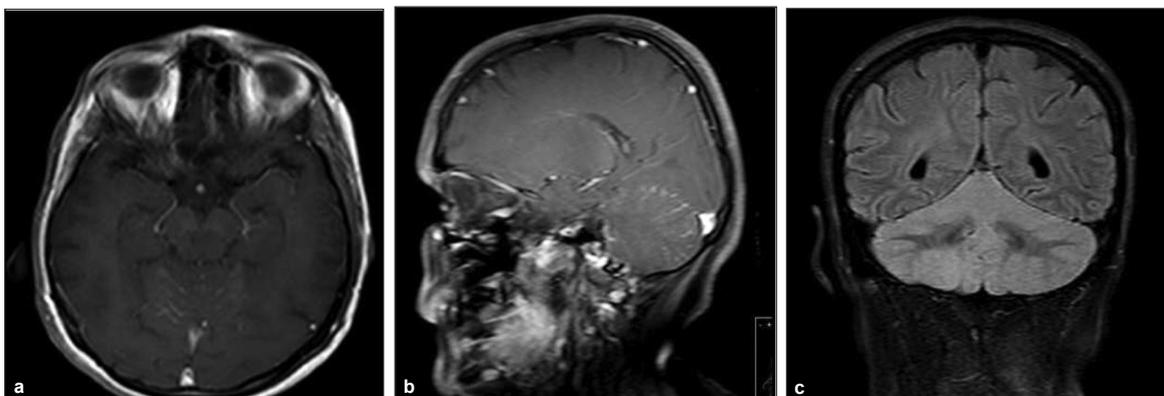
a) Linear leptomeningeal enhancement of contrast can be seen in post-contrast series on axial T1-weighted magnetic resonance images, b) Linear leptomeningeal enhancement of contrast can be seen in post-contrast series on sagittal T1-weighted magnetic resonance images, c) Diffuse hyperintense appearance on coronal T2-flair magnetic resonance images of the cerebellum.
